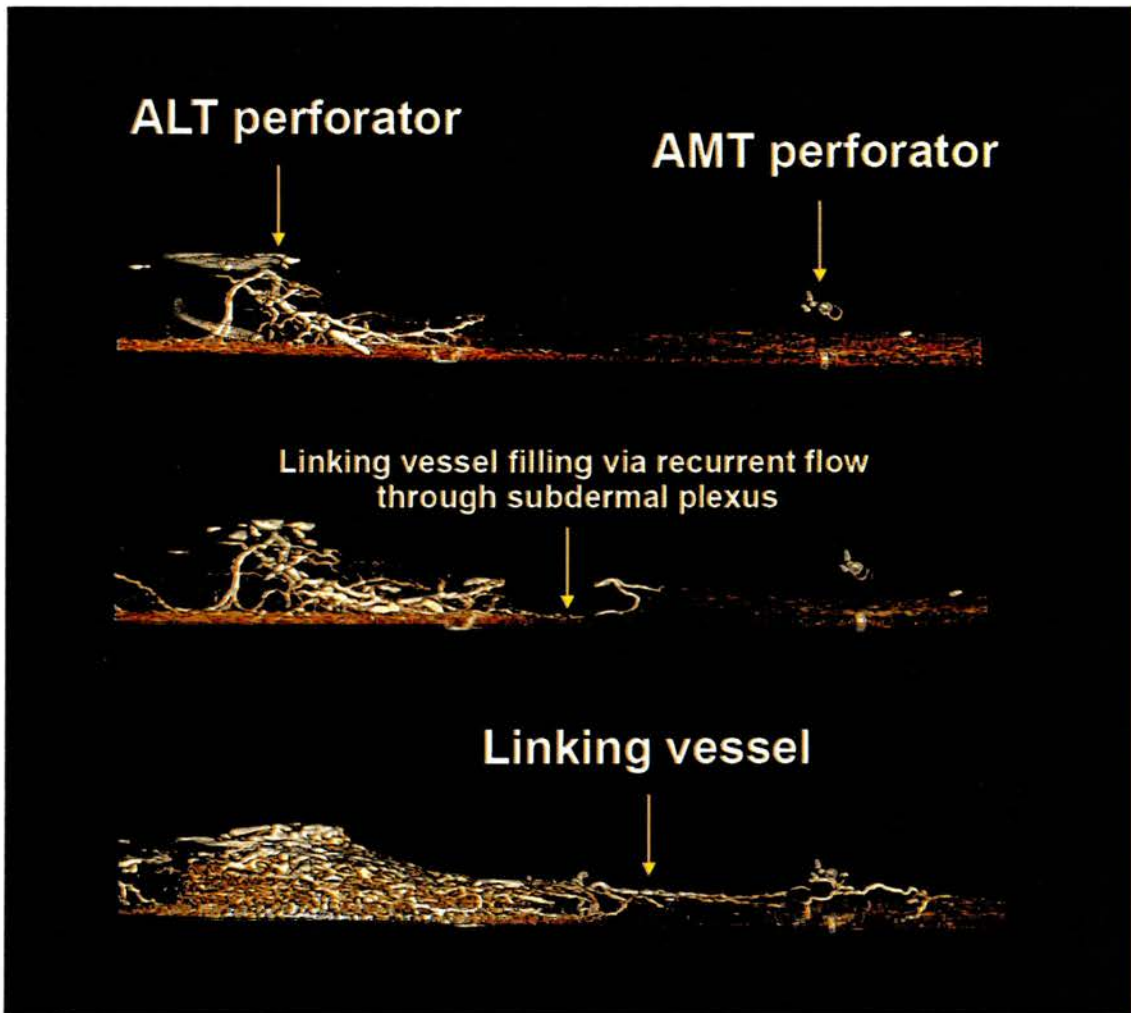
Lateral dynamic computed tomographic angiographic images of a type III perforator complex in an anterolateral thigh (ALT) flap. Images are acquired at 0.5-ml injection intervals and clearly show the dense suprafascial plexus and recurrent flow through the subdermal plexus.
